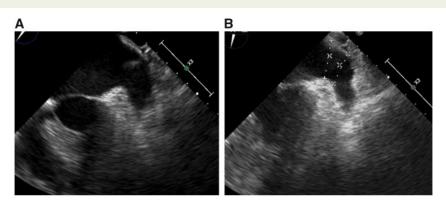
Two-dimensional transoesophageal echocardiography image of left atrial appendage (A), diameters of left atrial appendage ostium and 10 mm distal to ostium (B). LAA, left atrial appendage; TOE, transoesophageal echocardiography.
